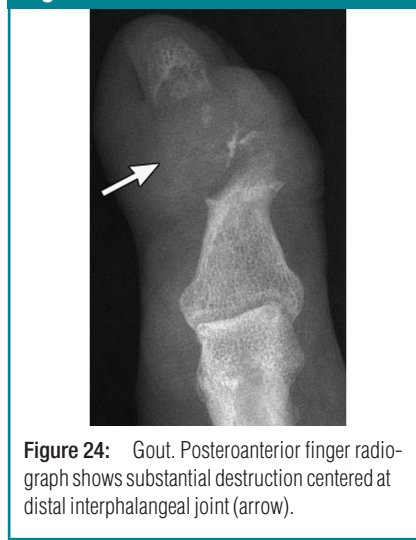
Gout. Posteroanterior finger radiograph shows substantial destruction centered at distal interphalangeal joint (arrow).
